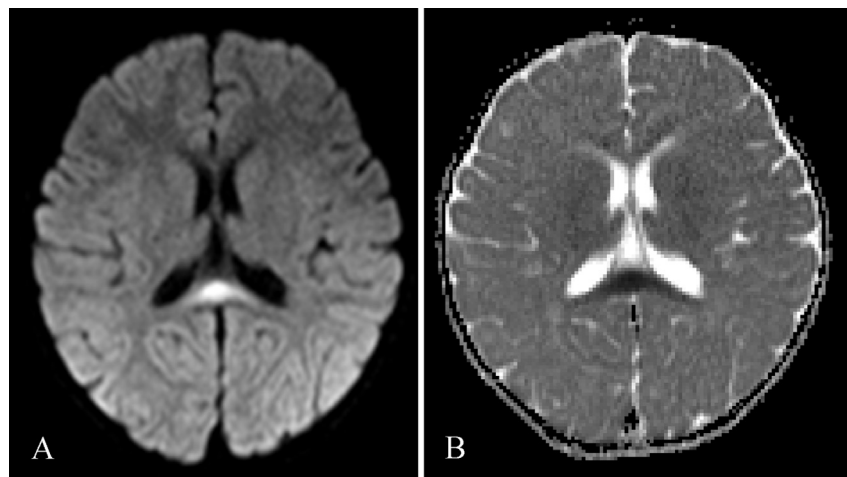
Girl, 1 year and 8 months, fever and vomiting for 3 days, diarrhea for 2 days, convulsions once, MERS type I, splenium of the corpus callous lesion, DWI (A)revealed high signal intensity and ADC(B) graph revealed low signal intensity.
